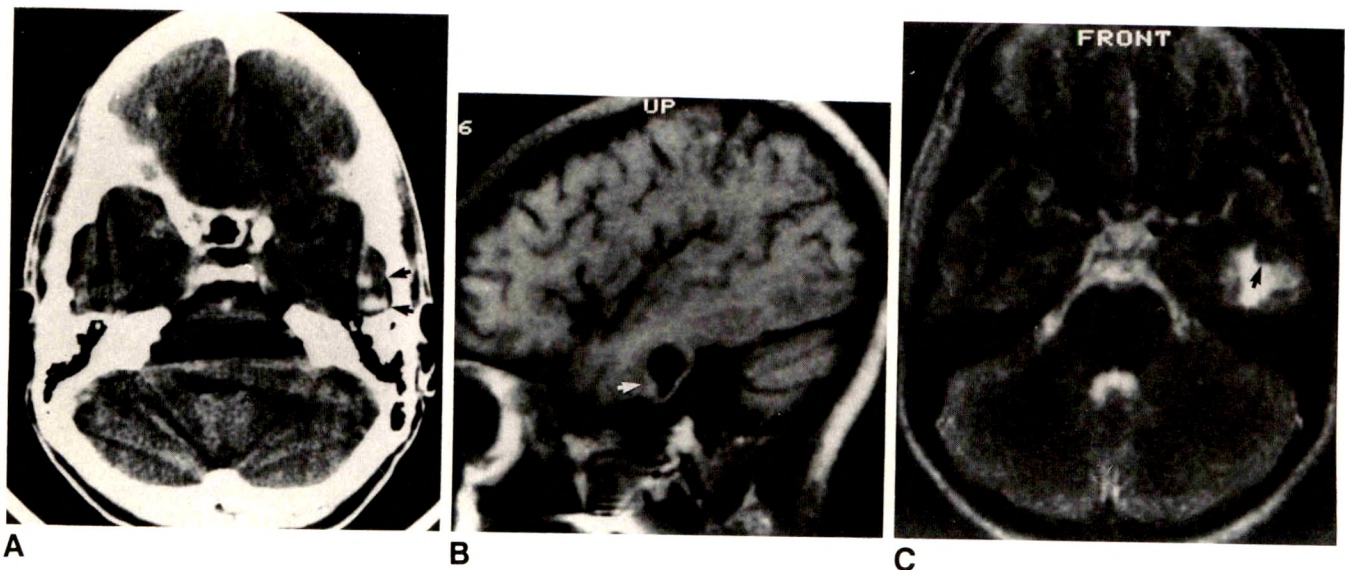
A–C, Contrast CT (A), T1-weighted, 500/30 (B), and T2-weighted, 2500/90, (C) MR images of a pure low-grade oligodendroglioma. Tumor calcifications (arrows in A) are far better appreciated on CT. However, the tumor margins and cystic component, obscured by computer artifacts on CT, are clearly shown on MR. Solid tumor nodule (arrows in B and C), proved at surgery, is sharply demonstrated.
